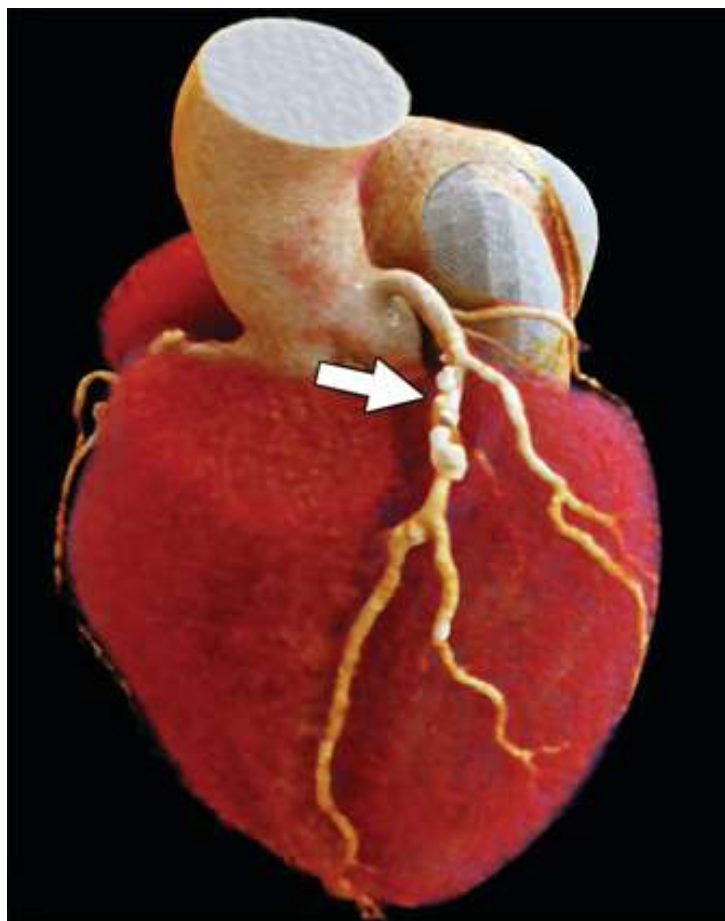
CT angiography of the heart and coronary arteries is being performed on a 70-year-old man who has chest pain.
